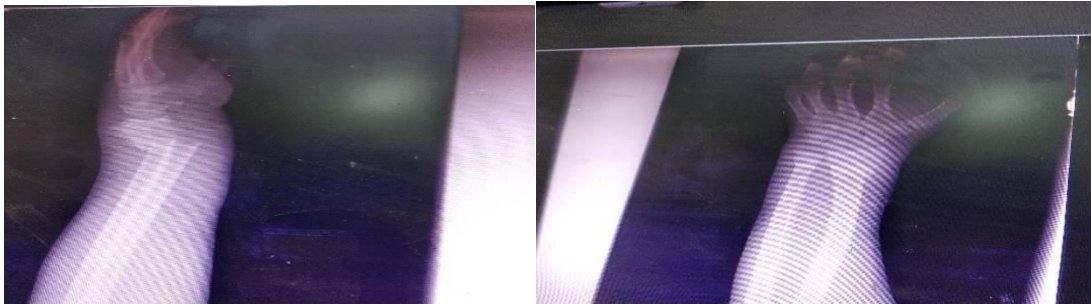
Pre-operative X-ray A-P and lateral views of the case (2)
